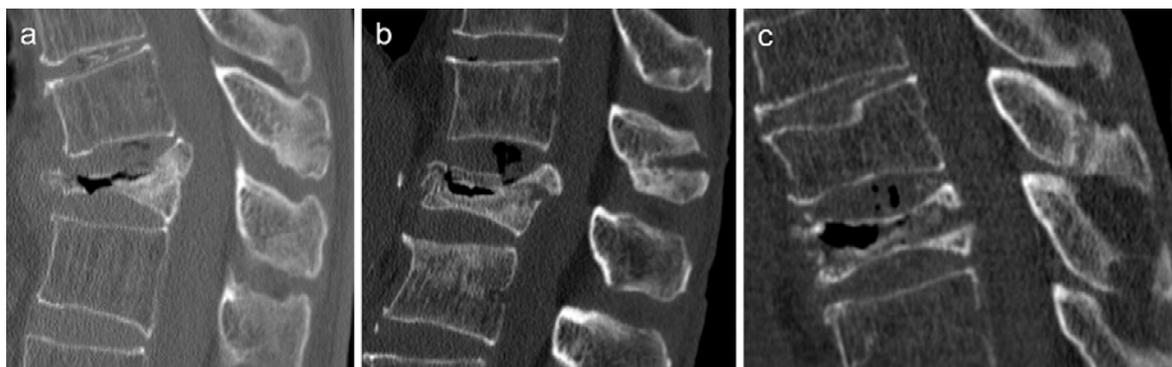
Sagittal CT indicating spinous process fractures (SPFs) (a: T11 osteoporotic vertebral fracture [OVF] with T10 SPF. b: L1 OVF with T12 SPF. c: T10 OVF with T9 SPF).
